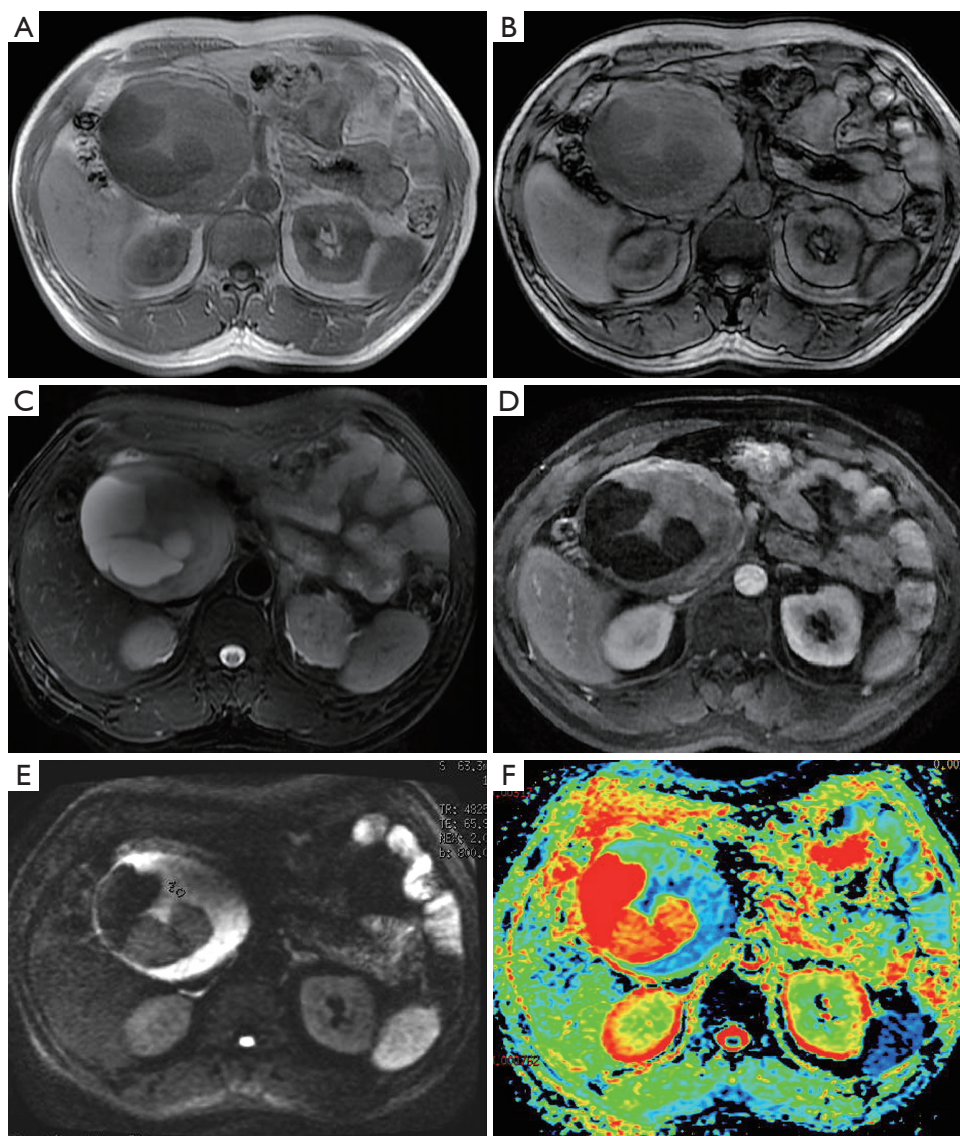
A female who is 52 years old. The mass was found on check-up for one month. The tumor had regular shape and well-defined margin, showed hypointense on T1WI/DUAL (A/B), heterogeneous hyperintense on T2WI/FS (C), and marked enhanced on enhanced MR imaging (D). And hyperintense on DWI (E). $ADC = 2.117 \times 10^{-3} \text{ mm}^2/\text{s}$ (F). Pathology: neurofibroma.
